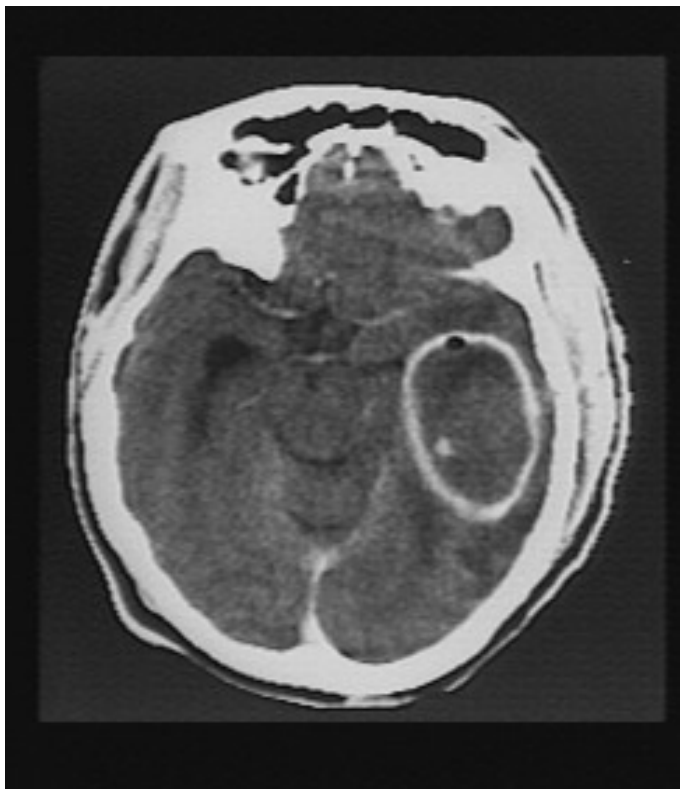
CT scan of a cerebral abscess
